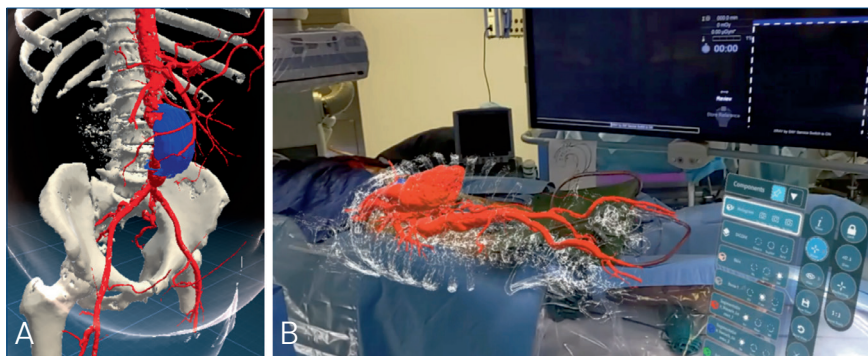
• Visualization of the hologram with computed tomography reconstruction, and placement of the hologram on the patient lying on the operating table.
